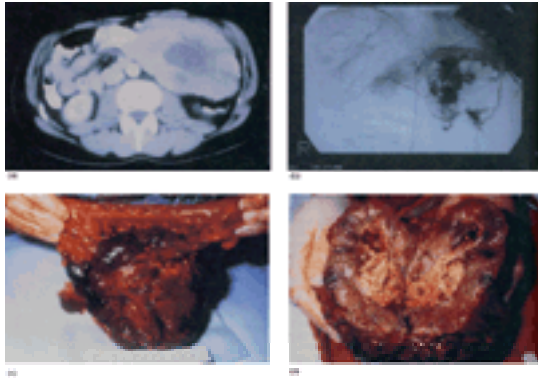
Malignant stromal tumour of the fourth part of the duodenum. A 27-year-old man presented with melaena and a palpable abdominal mass. (a) CT scan showed a large tumour arising in close proximity to the tail of the pancreas. (b) Visceral angiography clearly demonstrates the neovascularization associated with the tumour. (c) At operation, a large tumour arising from a narrow pedicle on the fourth part of the duodenum was invading the transverse mesocolon; thus a small-bowel and colonic resection were carried out. (d) The cut surface of the tumour showed central necrosis.
